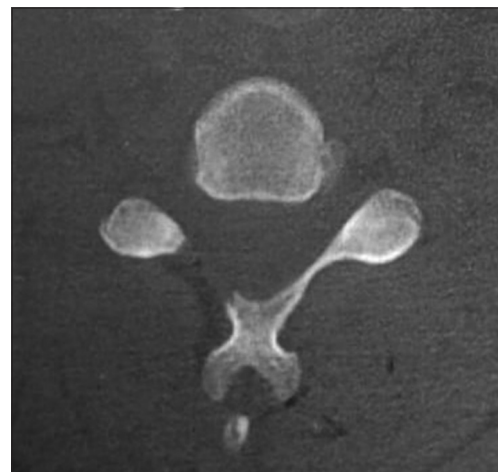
Axial cervical computed tomography images after surgery showing complete hematoma evacuation with the right hemilaminectomy.
